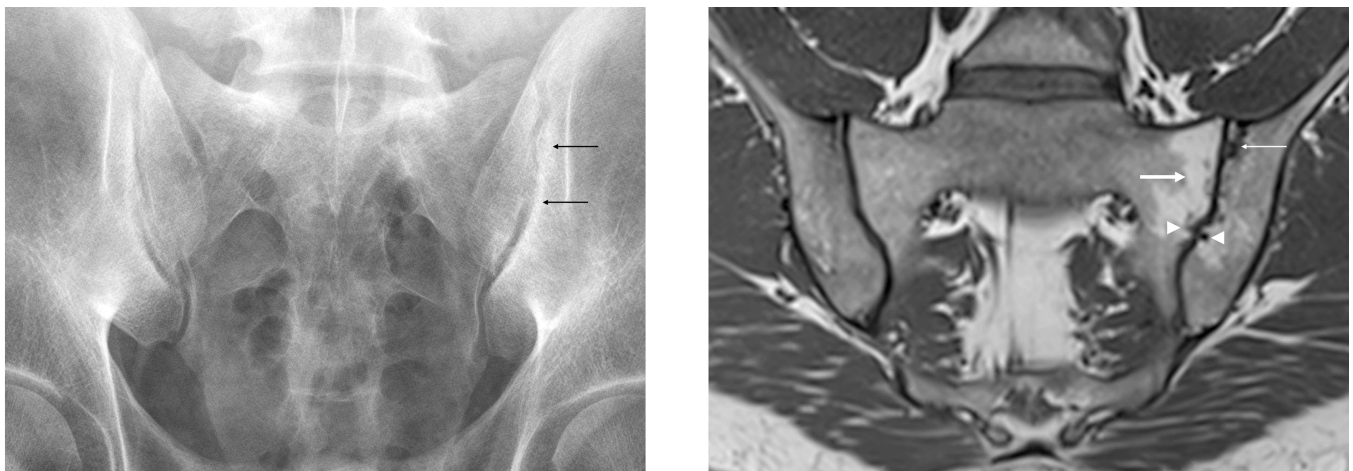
Radiograph (A) and MRI in a T1-weighted sequence (B) of sacroiliac joints (SIJ) of a 30-year-old patient with nonradiographic axial SpA. A: normal right SIJ (score for erosions 0, subchondral sclerosis 0, joint space change 0, sacroiliitis grade 0) and suspicious changes (possible subchondral sclerosis, thin arrows) of left SIJ (score for erosions 0, subchondral sclerosis 1, joint space change 0, sacroiliitis grade 1) are seen. B: right SIJ is normal (all scores 0); on the left side, subchondral sclerosis (thin arrow) and definite erosions (arrowhead) are evident (score for erosions 2, subchondral sclerosis 2, joint space change 0, sacroiliitis grade 2). In addition, a large fatty lesion is present (thick arrow). MRI: magnetic resonance imaging; SpA: spondyloarthropathy.
